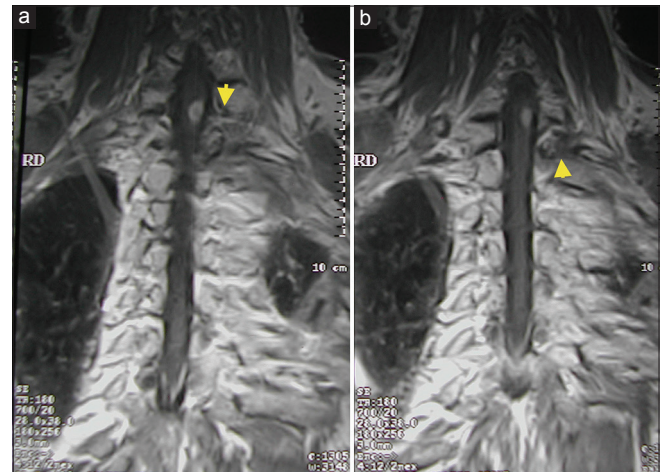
Coronal T1-weighted magnetic resonance images of the cervicothoracic spine after gadolinium injection demonstrating a well-shaped enhancing mass in the spinal cord at the C6–C7 level. Images showing no evidence of (a) perimedullary or paravertebral (b) mass (yellow arrowheads)
